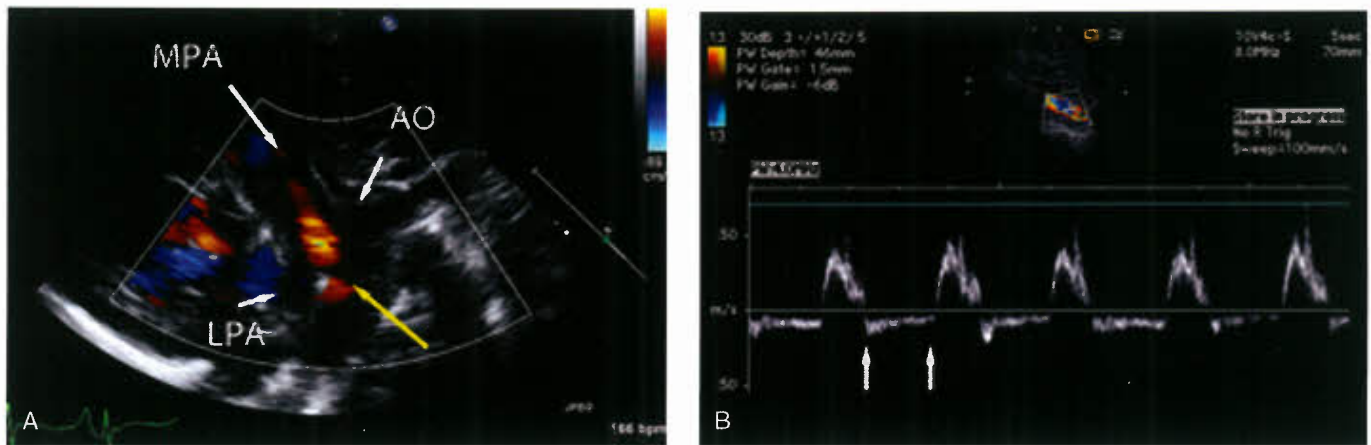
A: Echocardiogram in suprasternal view showing patent distal aortic arch and reversed ductal flow (red) from the ductal ampulla into the main pulmonary artery. B: Subcostal sagittal view showing holodiastolic flow reversal in the abdominal aorta.
